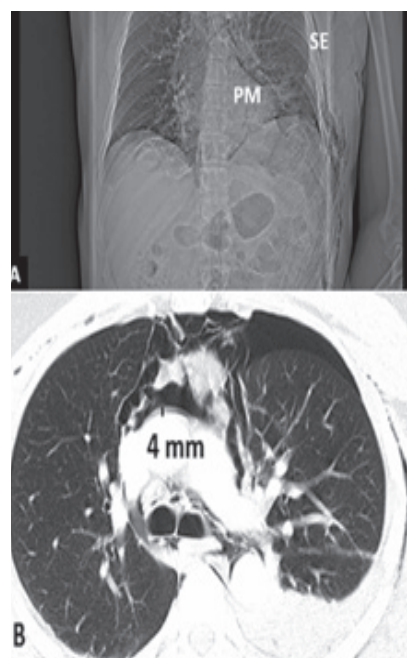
CT scan (120 kV, 436 mA, IV contrast) A: pneumomediastinum (PM), left side pneumothorax (PT) and subcutaneous emphysema (SE); B: pneumopericardium of 4 mm.
